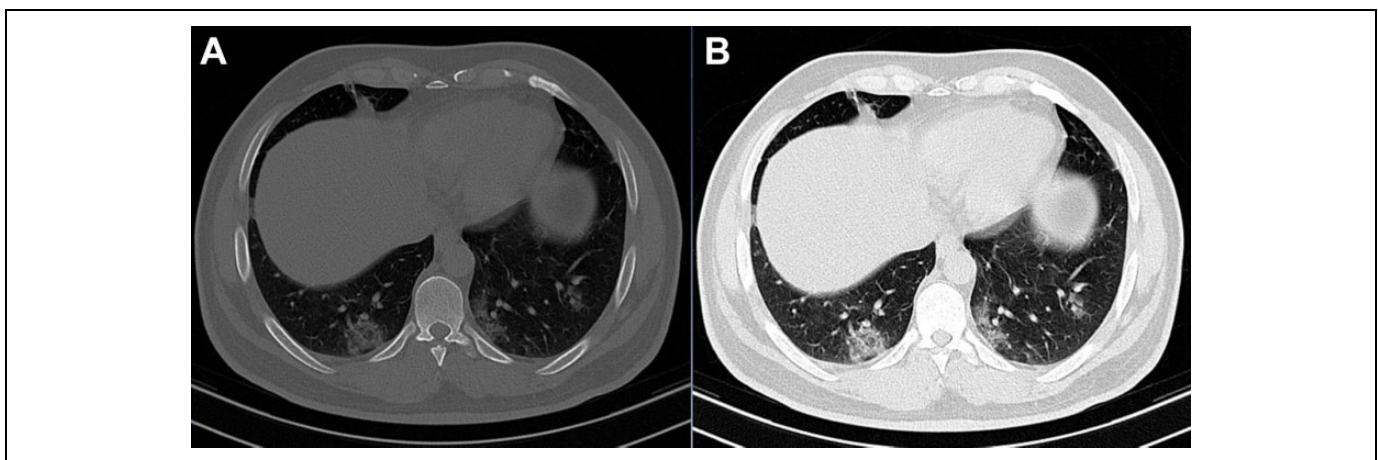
A single transaxial thoracic CT image with bone window (A) and with lung window (B) displayed. Pixel values in window width ranged from 1800 to 2200 for bone and 300 to 1100 for lung.
